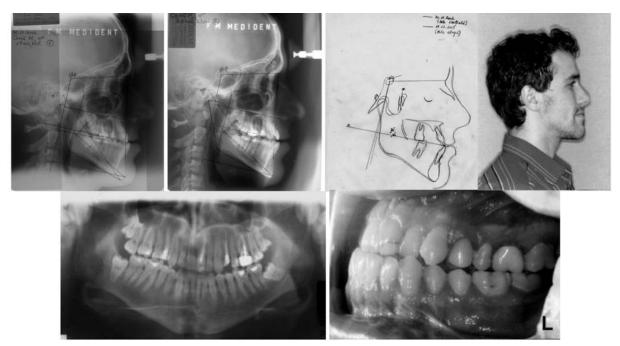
Patient C. M., male, lateral skull radiographs at the ages of 17 years and 10 months, 20 years and 2 months; tracings superimposition, profile aspect, orthopantomogram, intraoral aspect
